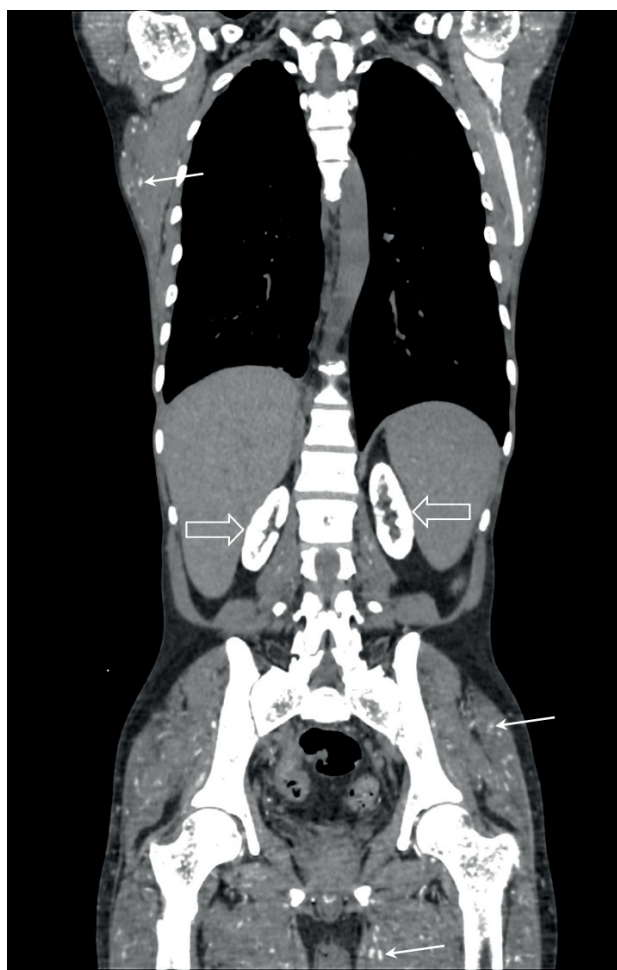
CT scan with coronal reconstruction showing heavy cortical calcification of the kidneys (open arrow) and innumerable small calcifications in the skeletal muscles seen as punctate white spots (arrows).
